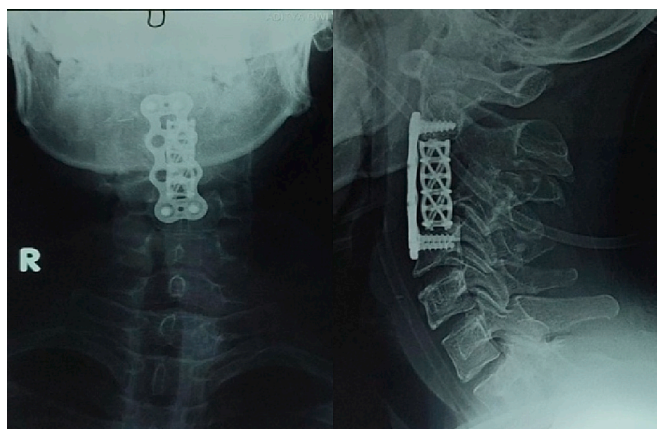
Postoperative Cervical X-ray AP/ Lateral.
